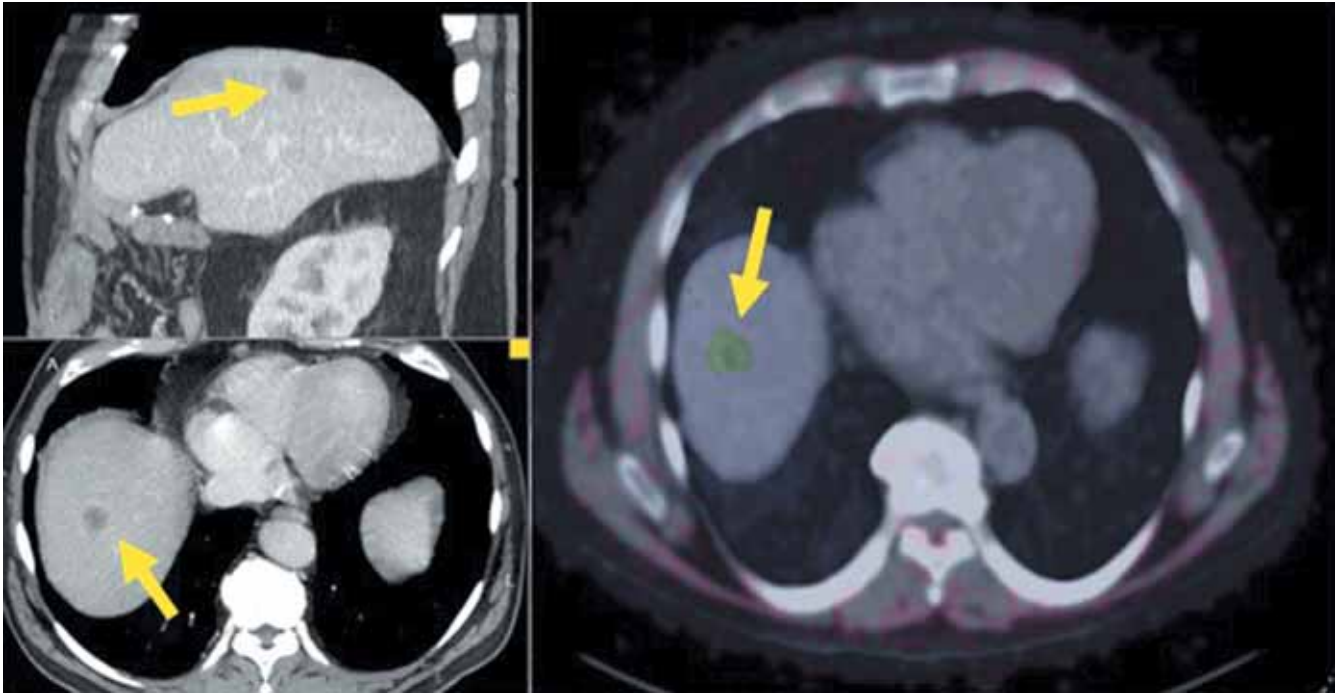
Computed tomography and positron emission tomography images in a patient. Metastasis is indicated by an arrow
